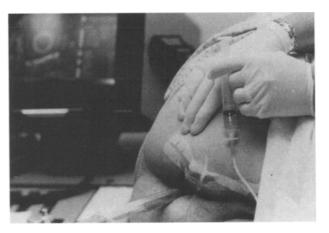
Hydrogen peroxide injected into fistula tract during anal endosonography.
